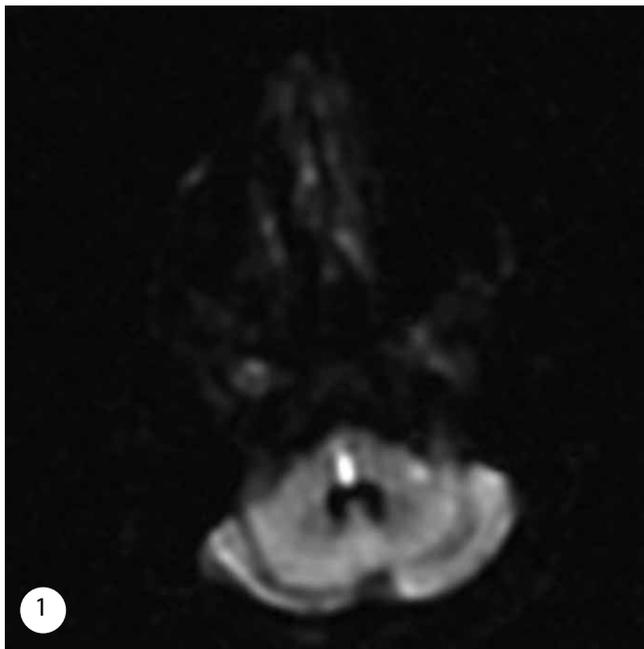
and Figure 2. Diffusion weighted images (DWI) showed high signal intensity lesion (corresponding to the anatomical correlate) in the brainstem.
